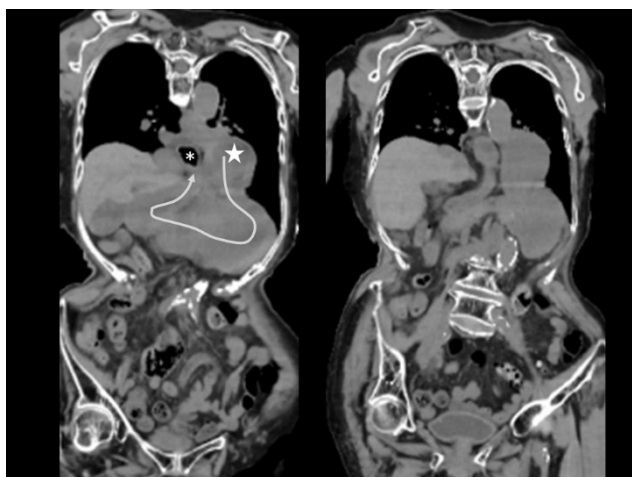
Trunk computed tomographic image (CT) on arrival
